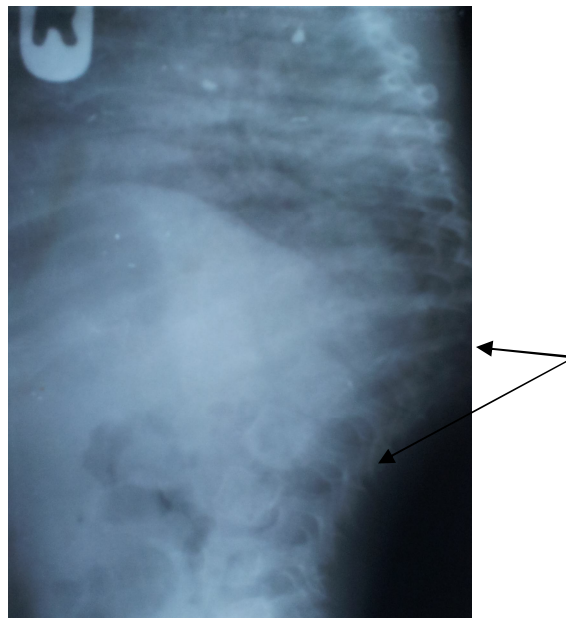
Spinal radiograph with black arrow showing lytic vertebral and disc destruction, calcifications, intervertebral space narrowing and wedge collapse (Gibbus)
